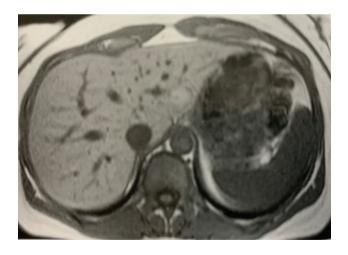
MRI liver and spleen. Idenity: liver, aorta, crura, inferior vena cava, spleen, stomach
